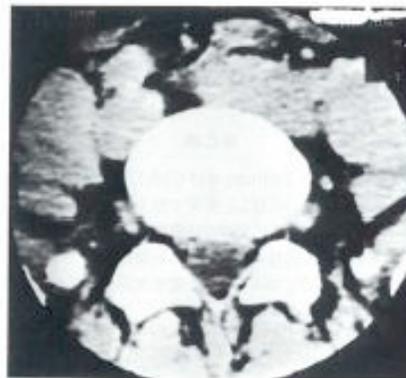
CT taken after 8 month's therapy. Reduction of neurological abnormality is seen. Easing of pain was also reported.
